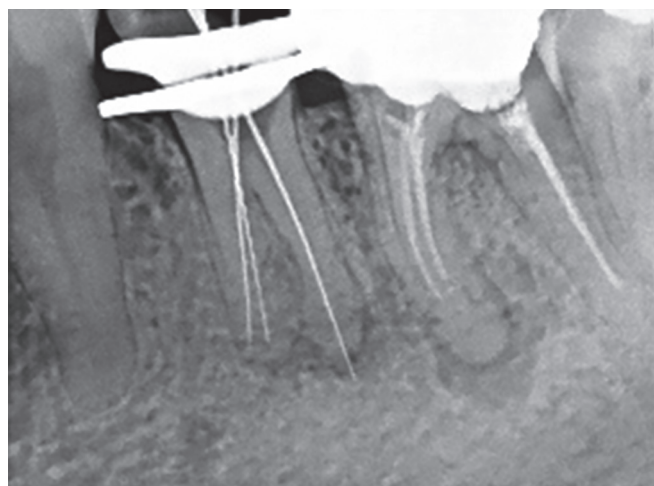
Working length radiograph of #35 showing three canals
